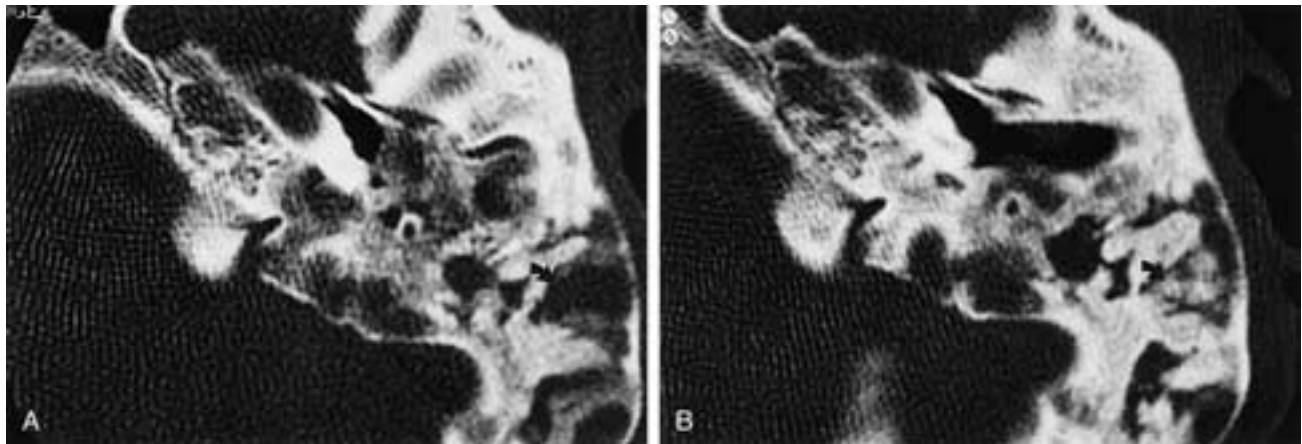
Monostotic fibrous dysplasia of the left mastoid. A, Axial CT shows a large, inhomogeneous mass with an intact cortex occluding the EAC and the tympanic cavity. The facial nerve canal is well preserved. B, CT 1 year after canaloplasty shows partial ossification of a previously unossified component (*curved arrow*).
